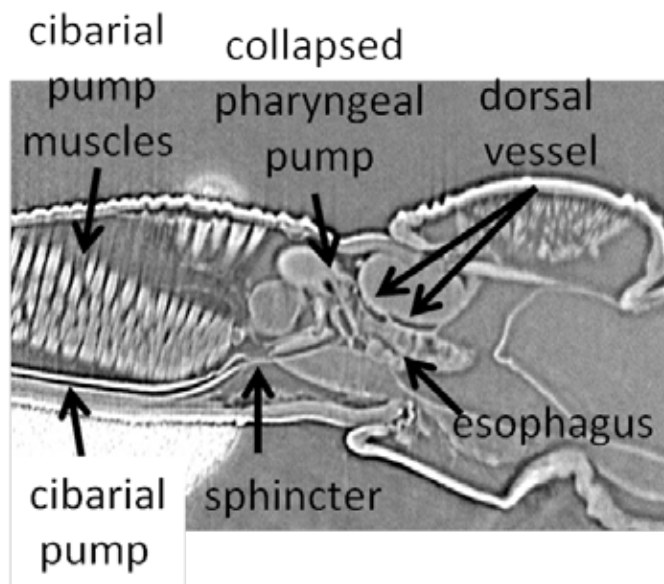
Example of the high resolution CT scan collected on 05B1-1 endstation: Cross section view of a CT scan of the blood-feeding insect *Rhodnius prolixus*, the vector of Chagas' disease. Courtesy of Juan Janowski.
